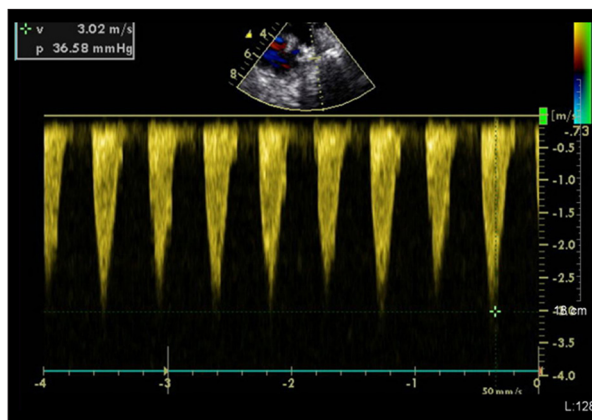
Transthoracic echocardiograms in suprasternal view in a 2-month-old (A) boy, showing high-speed flow in the CoA.
